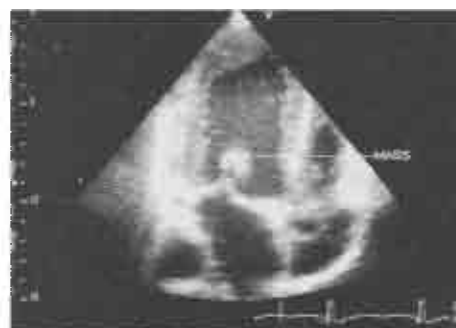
Case 2: Two dimensional trans-thoracic echocardiography image: Vegetation on anterior mitral leaflet
